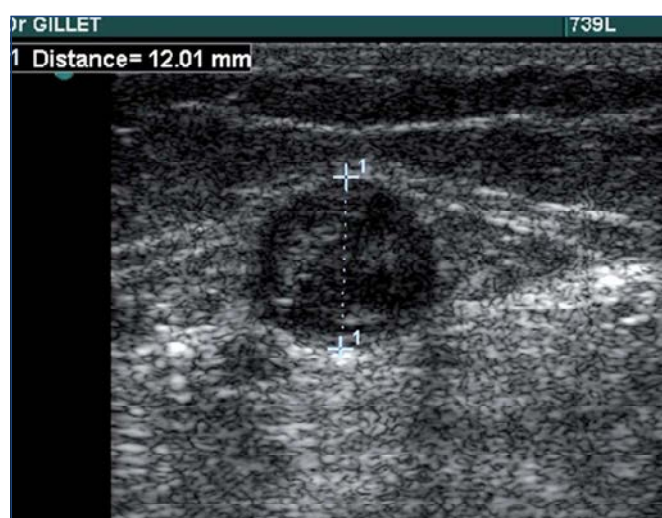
Ultrasound of thrombosis of the small saphenous vein.
